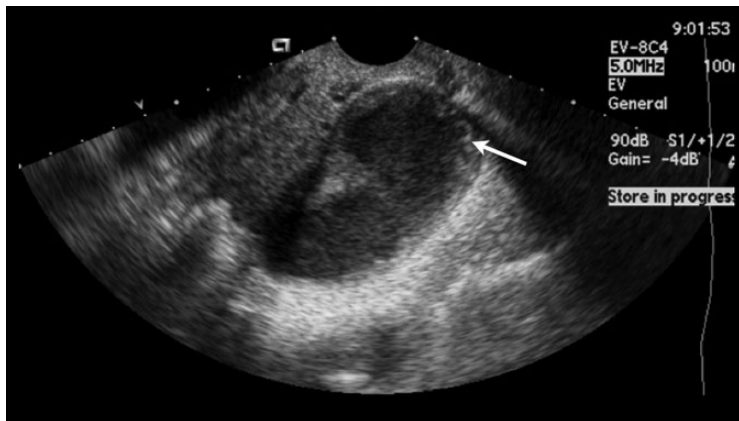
Pyosalpinx. Sagittal endovaginal ultrasound shows a distended fallopian tube with thickened wall with cogwheel phenomenon (arrow) and low-amplitude internal echoes, related to purulent material.
